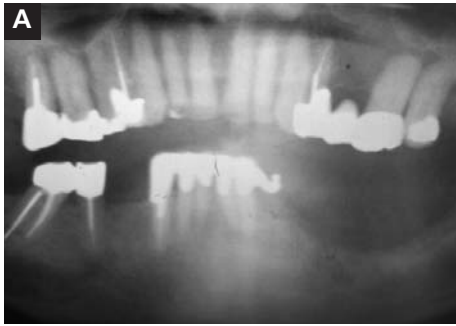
Initial presentation radiograph of 68-year-old man before loss of mandibular anterior bridge.
